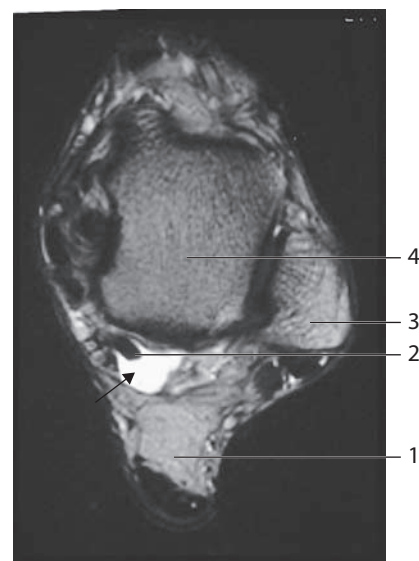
Magnetic resonance imaging of the flexor hallucis longus tendon. 1. Calcaneus 2. Flexor hallucis longus tendon 3. Fibula 4. Talus.
